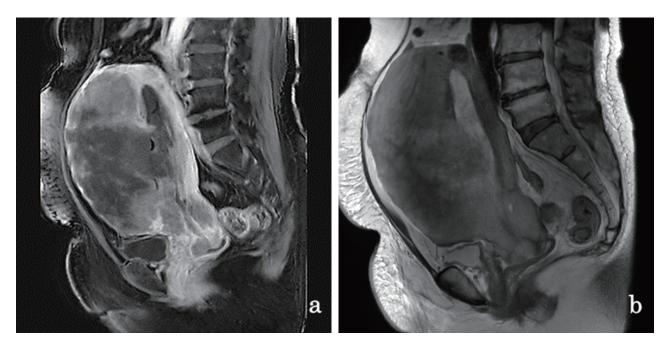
(a) Contrast-enhanced T1-weighted image. (b) Contrast-enhanced T2-weighted image. Preoperative MRI showed that almost all of the anterior uterine wall from the uterine body to the cervix was replaced by tumors.
